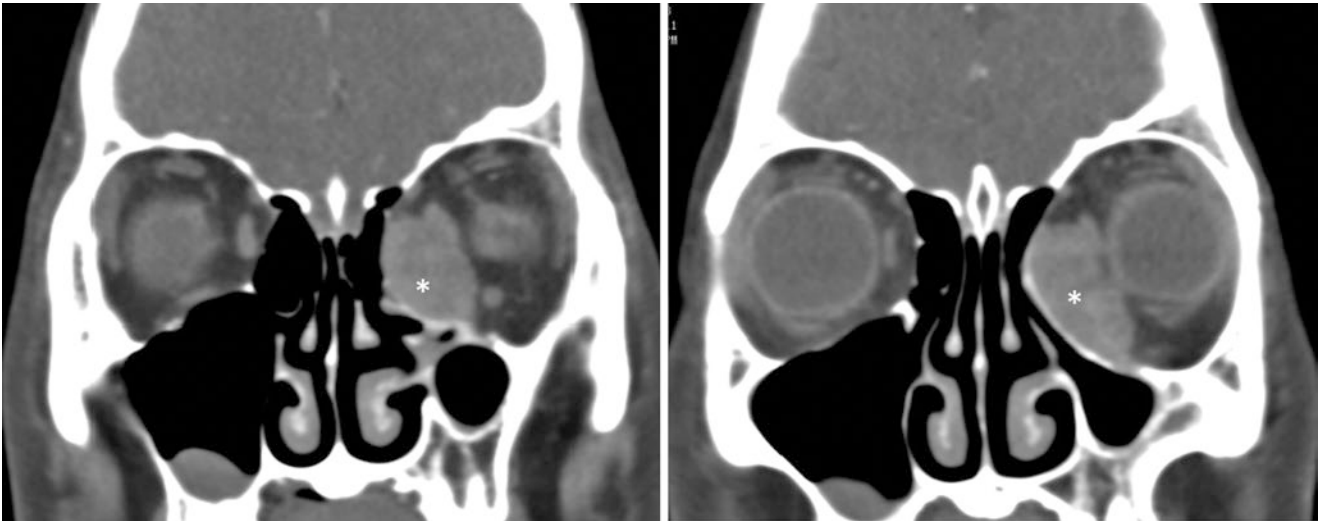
Coronal CT scan showing an extraconal multilobulated mass (asterisk) in the left inferomedial orbit with remodelling of the adjacent medial orbital wall
